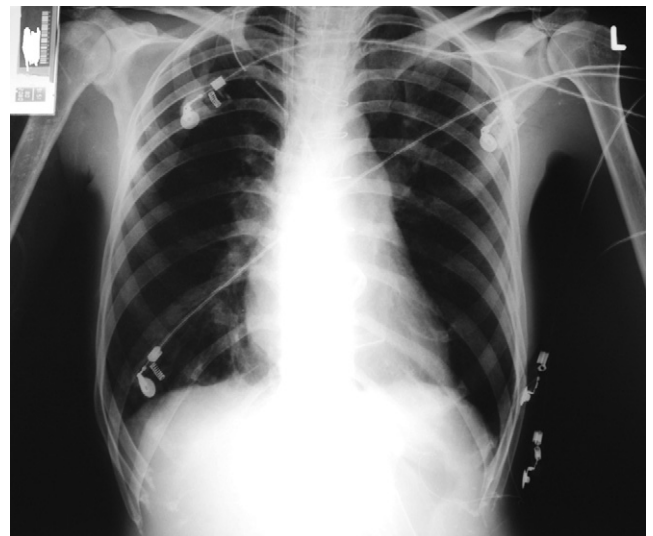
Postoperative antero-posterior projection X-ray.
